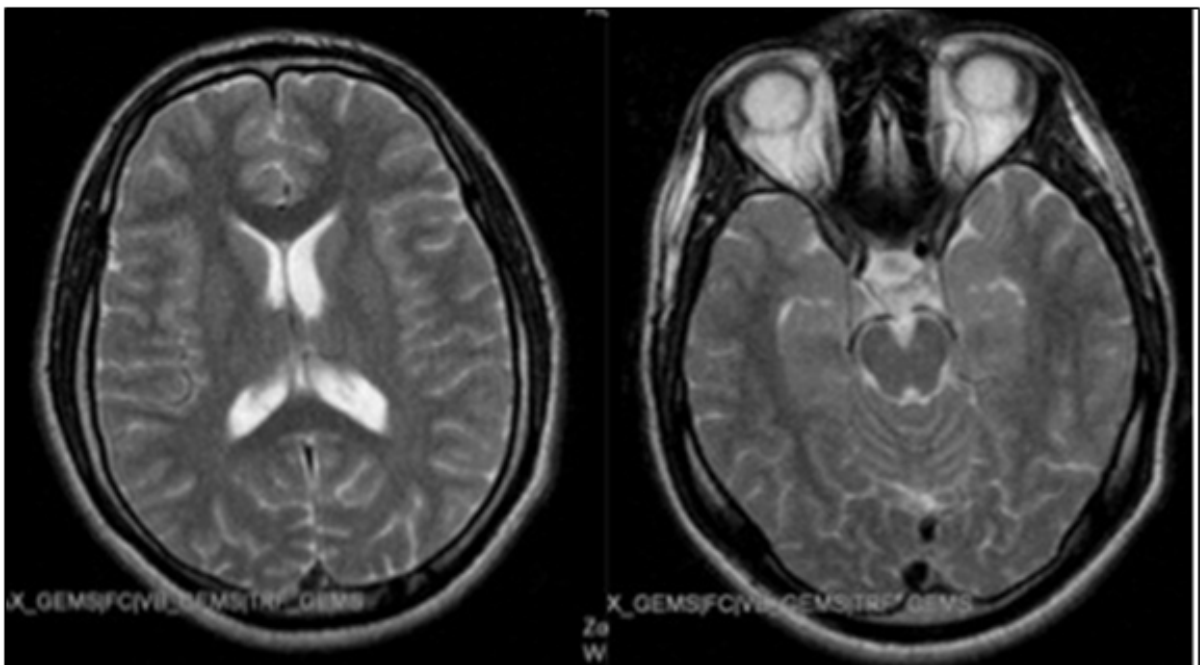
Brain MRI was by and large normal except mild lateral ventricular asymmetry.
